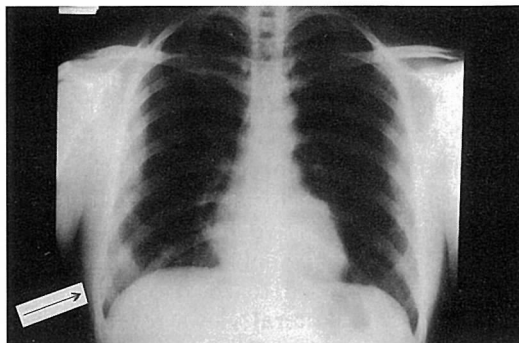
Initial chest radiography (Case 3) showing an infiltrate in the right S<sup>8</sup> (→). No abnormalities can be seen in the ribs.
